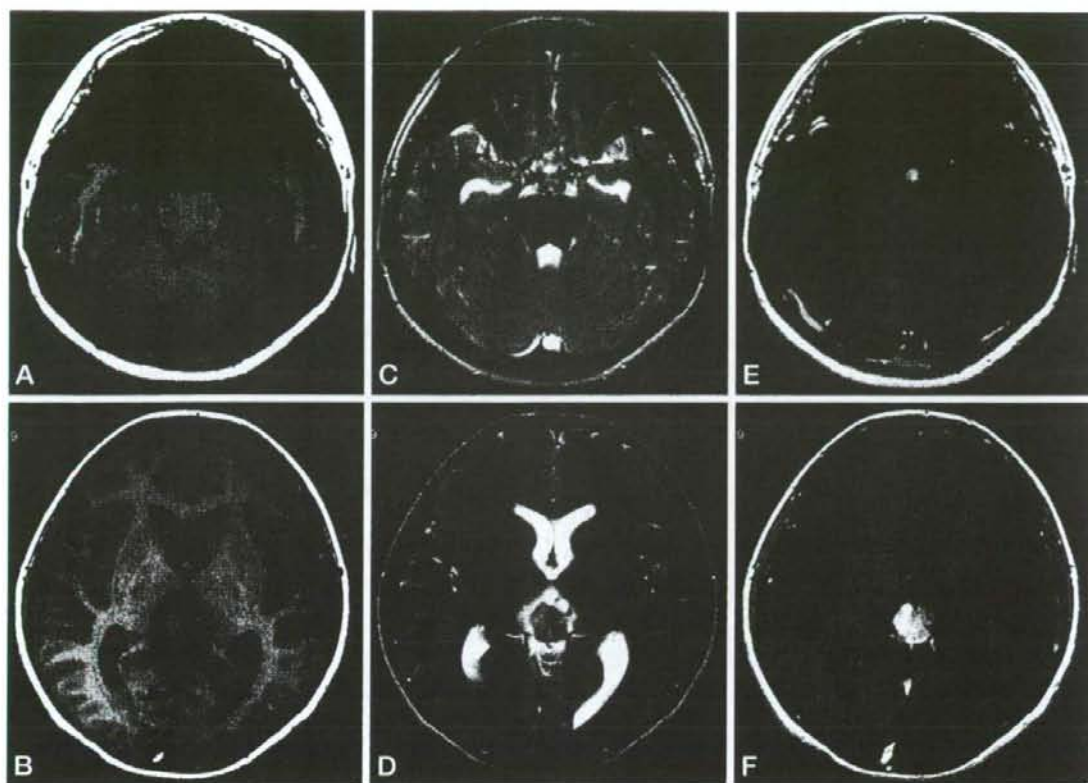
Preoperative MRI findings: Suprasellar and pineal region tumors were isointense on T1-weighted images (A, B) and T2-weighted images (C, D). Gadolinium-enhanced MRI demonstrated homogeneous enhancement (E, F).
